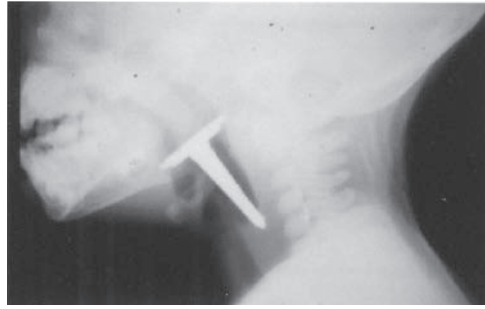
Radiograph of lateral soft tissue of the neck demonstrates a foreign body (nail) in the pharynx. (Used with permission from Dr. Gregory J. Schears.)
